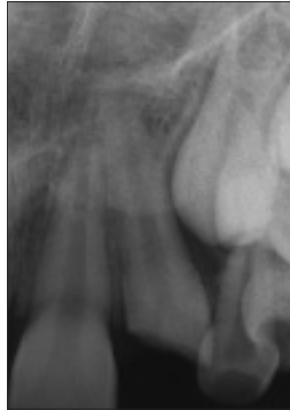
Radiographic appearance after severe intrusion of tooth 22 in the same patient.
